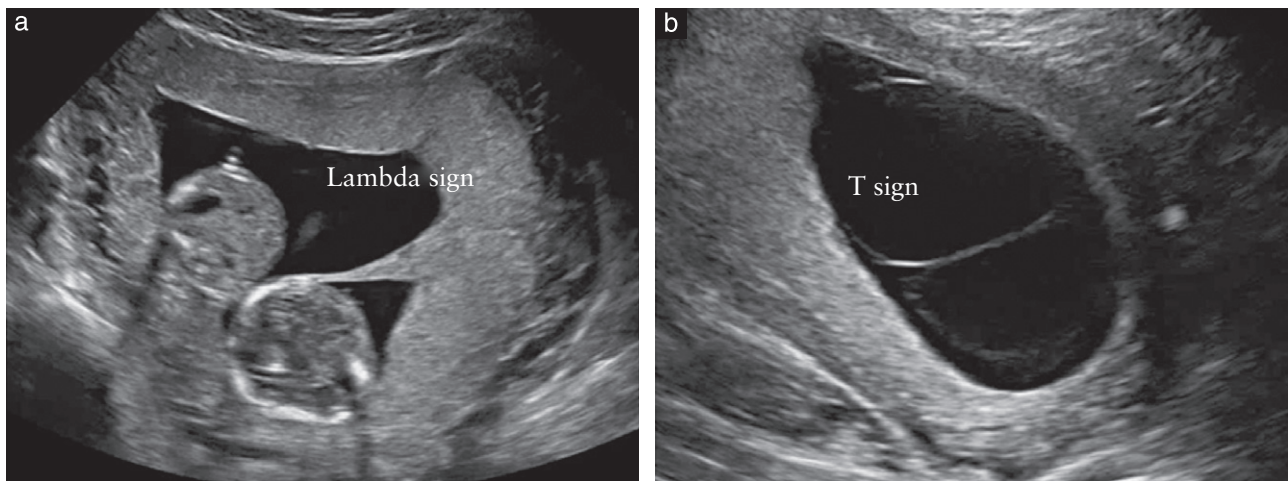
Ultrasound images in the first trimester of: (a) a dichorionic diamniotic twin pregnancy, in which the twins are separated by a thick layer of fused chorionic membranes; (b) a monochorionic diamniotic twin pregnancy, in which the twins are separated by only two thin amniotic layers.
